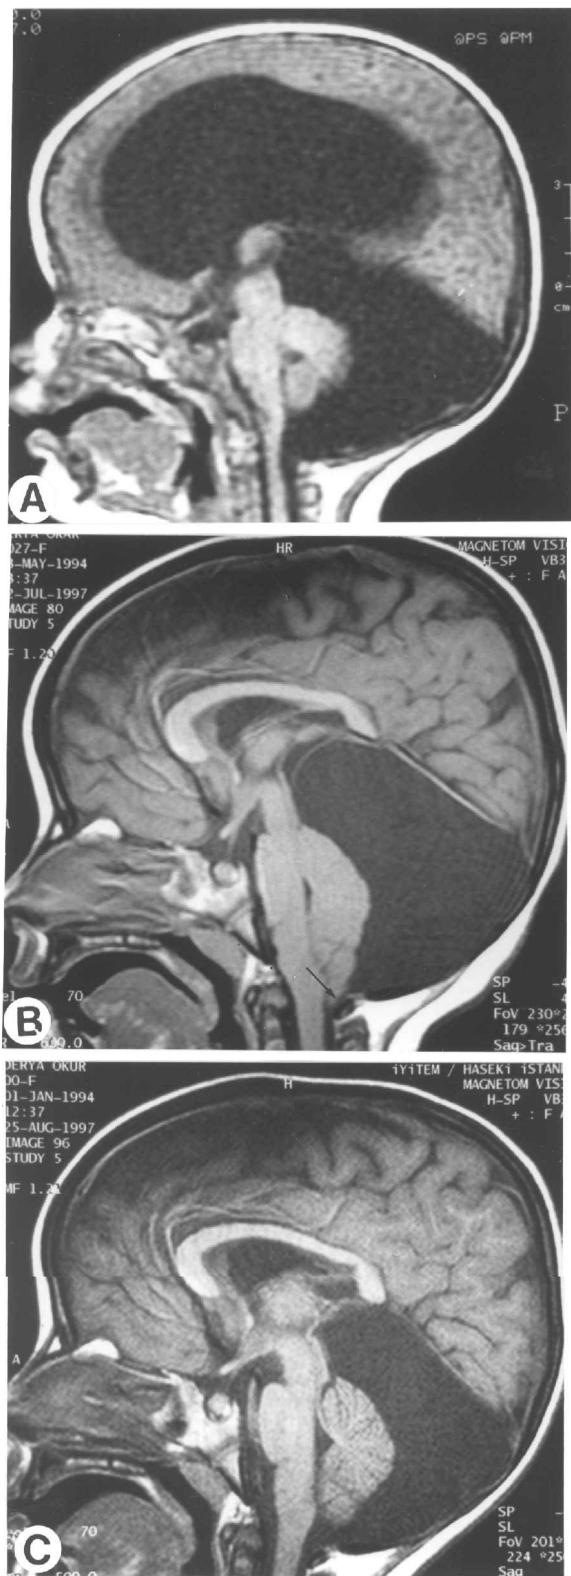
Case 12. (A) T1-weighted midsagittal MRI scan at 2 months of age shows retrocerebellar arachnoid cyst and marked non-communicating hydrocephalus. (B) 3 years after insertion of a VP shunt, the ventricular size was decreased, but the cerebellum and the brain stem were severely compressed by the enlarged cyst. There was a moderate herniation of the cerebellar tonsils below the foramen magnum (arrow). (C) One month after insertion of a CP shunt, the compression of the cerebellum and the brain stem has disappeared. Note that the posterior fossa is not enlarged and the torcular herophilli is normally positioned.
